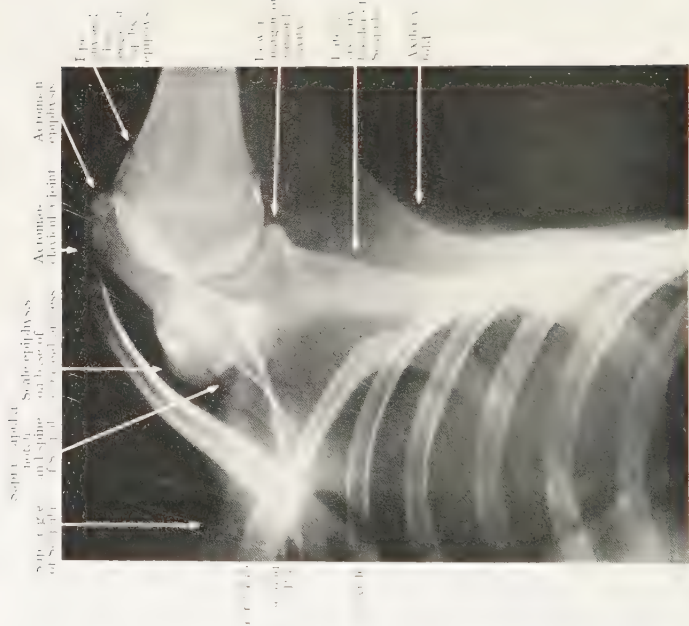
Radiograph of same Shoulder — arm adducted to right angle. Note the change in positions of Scapula and head of Humerus.
